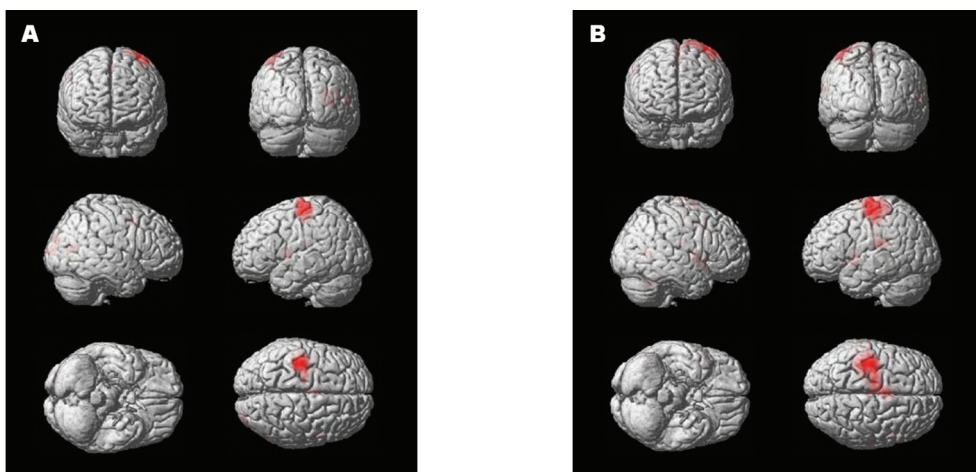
Cortex activation areas identified from the functional magnetic resonance imaging analysis displayed on low intensity blood flow restriction training (A) and non-low intensity blood flow restriction training (B).
